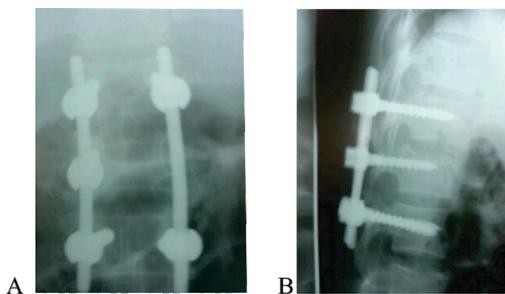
Post Operative Check X-ray Ap View(a) and Lateral View(b) Showing Deformity Correction.
